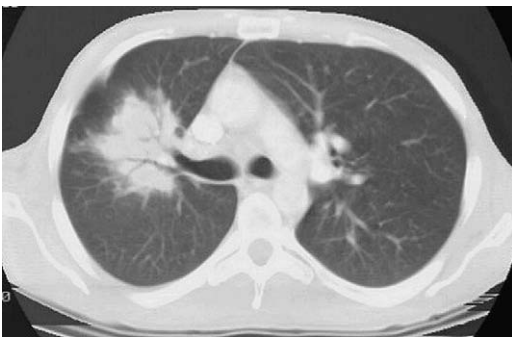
CT scan of blastomycosis appearing mass-like.
